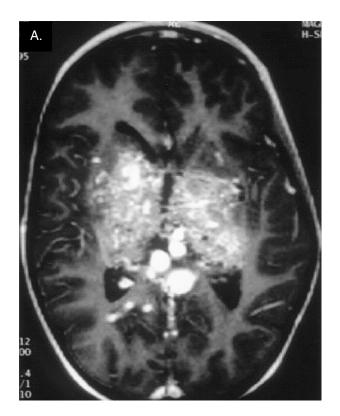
A,* Large, bilateral, thalamic arteriovenous malformation on contrast-enhanced, axial magnetic resonance imaging. *B,* Coronal view of magnetic resonance angiography in the same patient reveals the extensive, bilateral nidus of the lesion.
